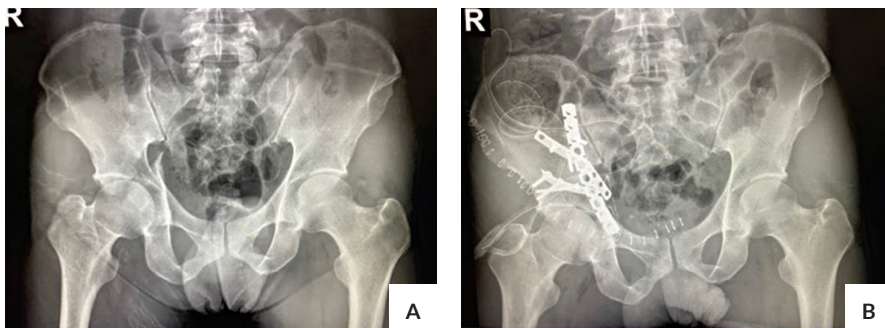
Radiographs from Patient 7 – Male, 48-year-old, car accident. (A) Preoperative, (B) Immediate post-operative.
